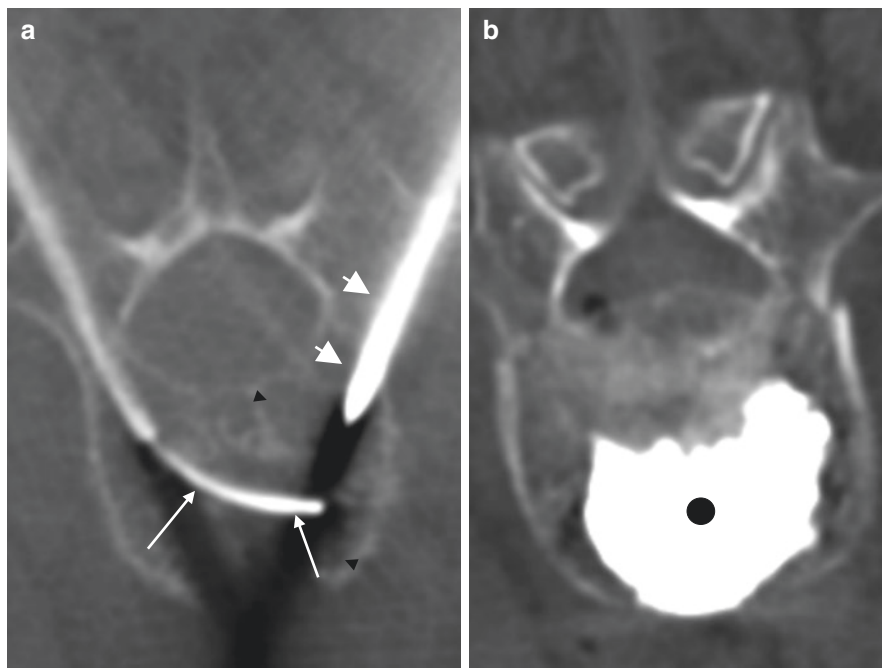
Computed tomography guidance with an articulating RF probe (white arrows) targeting a metastatic lesion along the posterior portion of the central vertebral body (black circle)
